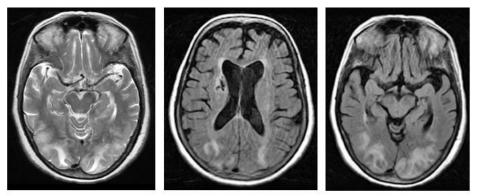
T2 & FLAIR hyperintensities in bilateral parieto-occipital regions – s/o PRES
